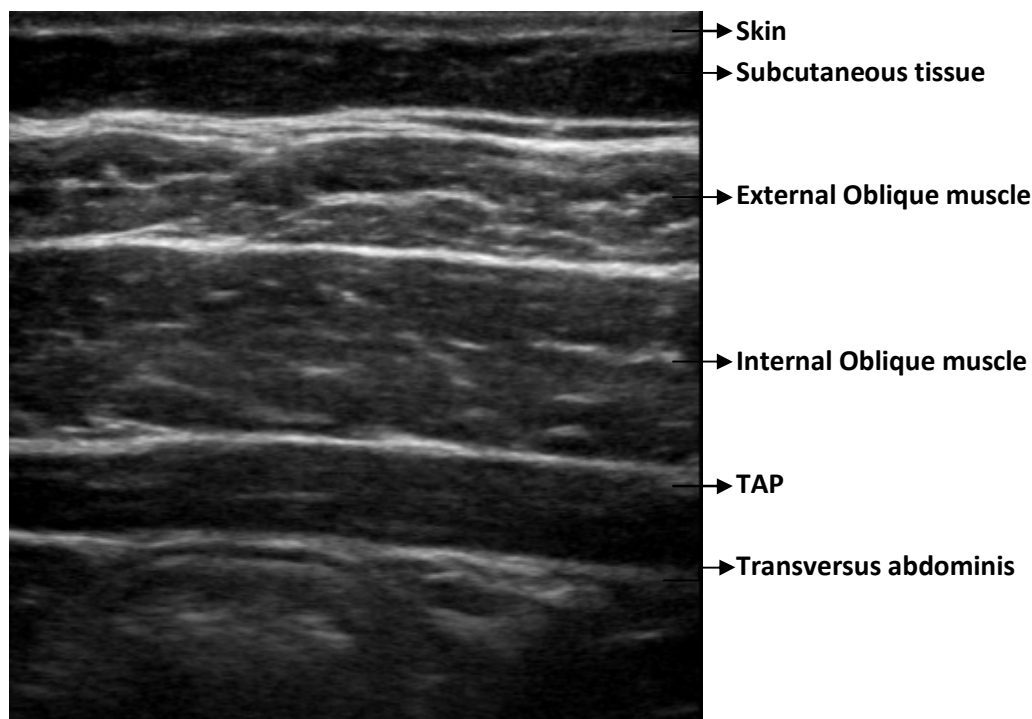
Ultrasound anatomy of TAP block
